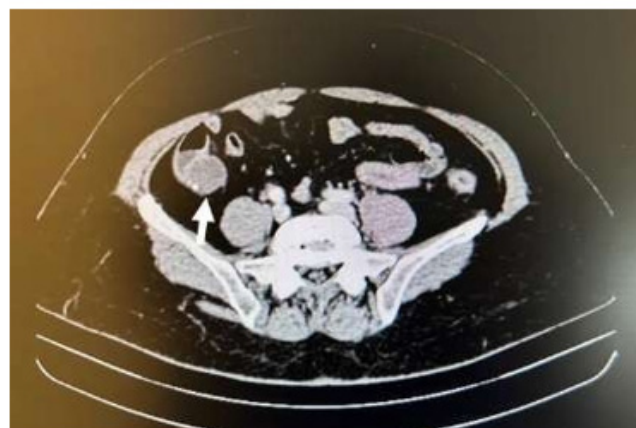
CT showing appendiceal mucocoele
